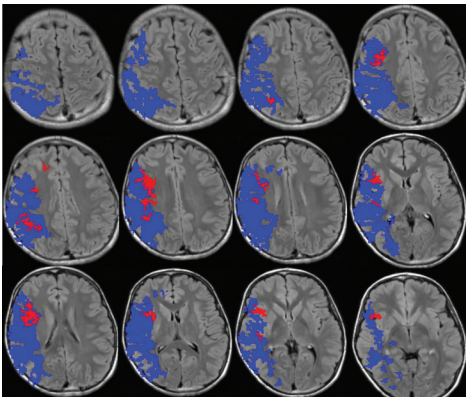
In Case 1, MRI with diffusion and perfusion weighted sequences processed using Olea Sphere (Olea Medical Solutions, Inc., Cambridge, MA) shows volume of core infarct in red and hypoperfusion in blue, consistent with a large area of ischemic penumbra in the right MCA distribution.
